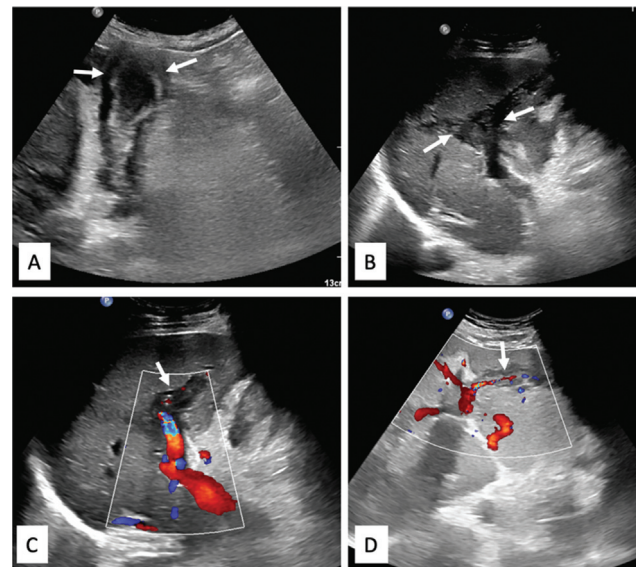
Grayscale ultrasonography (USG) images (A, B) showed partially distended gallbladder with homogeneously hypoechoic mural thickening with maintained hyperechoic mucosal outline and linear periportal hypoechoic areas. Color Doppler images (C, D) revealed attenuated caliber of the left and right portal vein branches.
